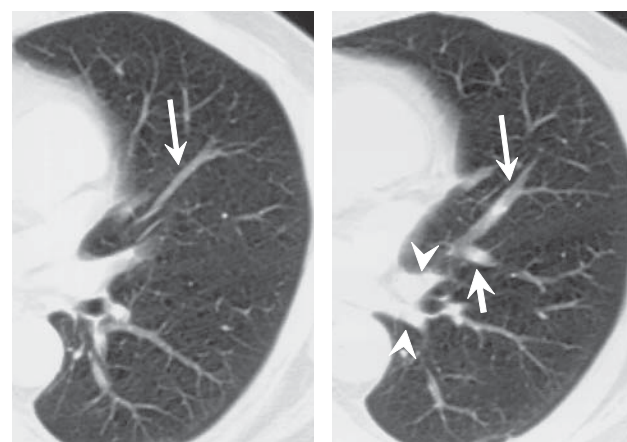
Retrospective review of the preoperative chest CT shows that the lingular vein (long arrow) merging with V^{8a} (short arrow) empties into the ventral trunk of the inferior PV. Two stems of the inferior PV are detectable in the CT (arrowheads).
